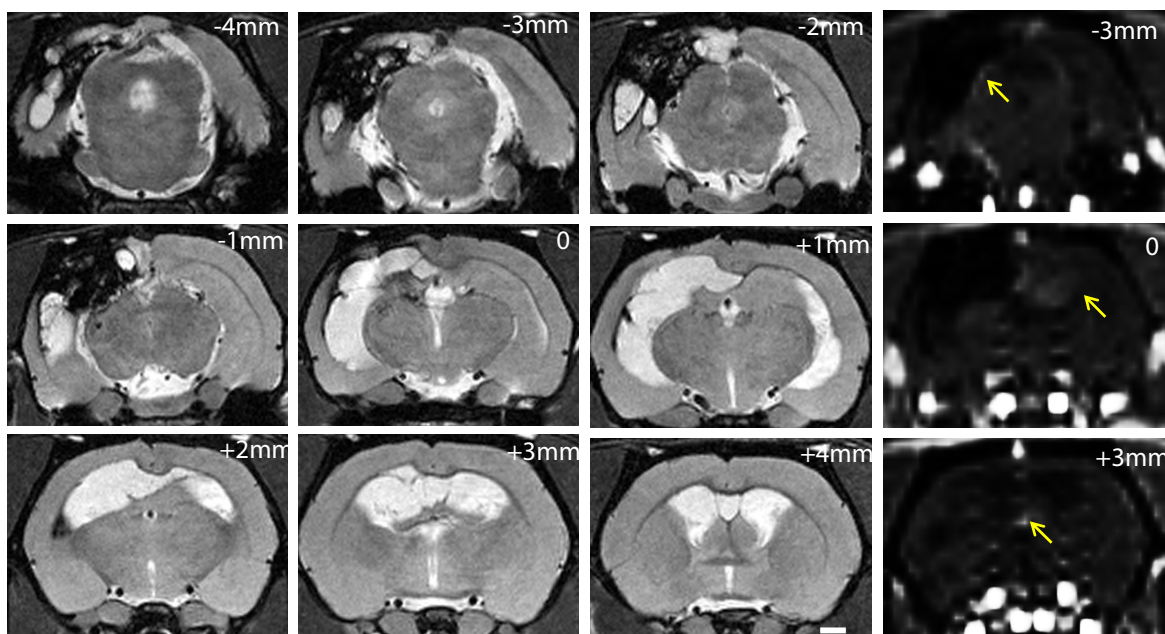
T₂- and T₁-weighted MRI of DXR alone treated tumor. DXR treated tumor at end of study showing coronal sections through the brain away from the site of implantation (center square) in 1mm increments. MRI showed incidence of tumor-type structures through the brain. Further, injection of Omniscan showed contrast enhancement on T₁-weighted images (far right, yellow arrows indicate regions of enhancement).
